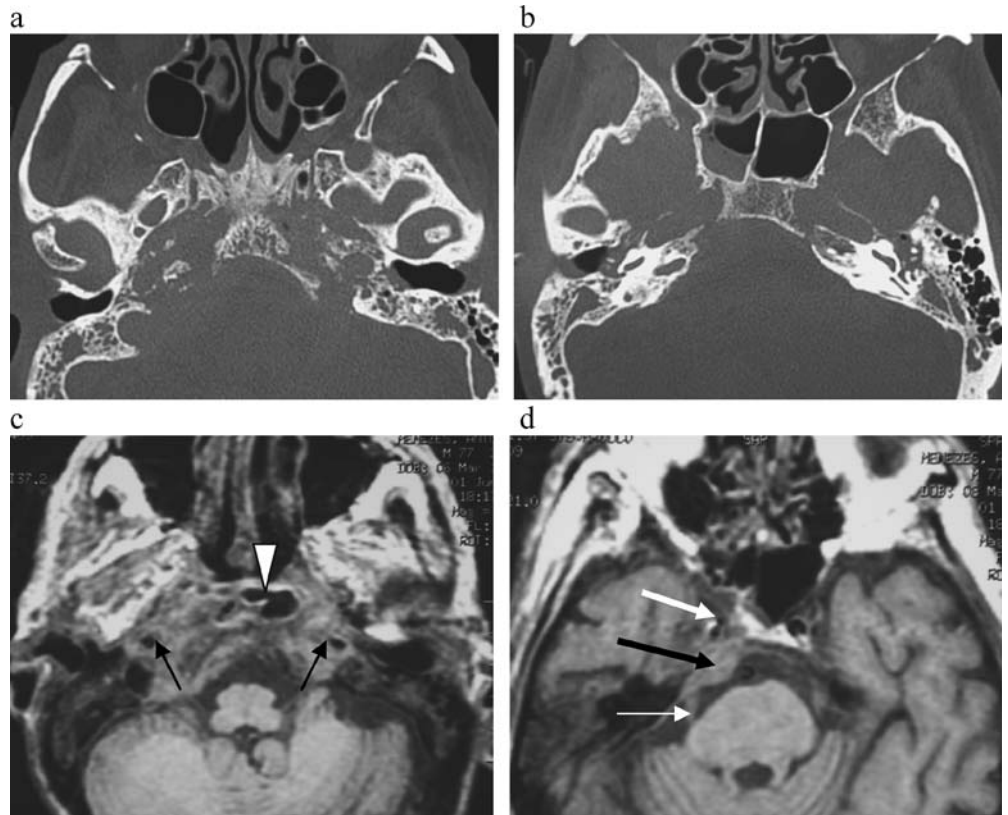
Skull base osteomyelitis with abscess formation in a diabetic patient presenting with Gradenigo's syndrome. a Axial CT (bone algorithm) and (b) axial T1W MR images through the central skull base demonstrate a permeative destructive bone pattern involving the central skull base including the clivus, petrous apices and jugular foramen, associated with bilateral opacification of the middle ear cavity and an air-fluid level in the sphenoid sinus. MR shows a soft tissue mass replacing the central skull base, encasing the petrous (thin black arrows) and cavernous internal carotid arteries (thick white arrow), filling in Meckel's cave on the right (thick black arrow) and extending posteriorly along the cisternal segment of the nerve (thin white arrow). Note the presence of a central region of very low T1W signal intensity corresponding to a pocket of fluid (a, white arrow-head). (Skull base osteomyelitis with abscess formation in a diabetic patient presenting with Gradenigo's syndrome)
